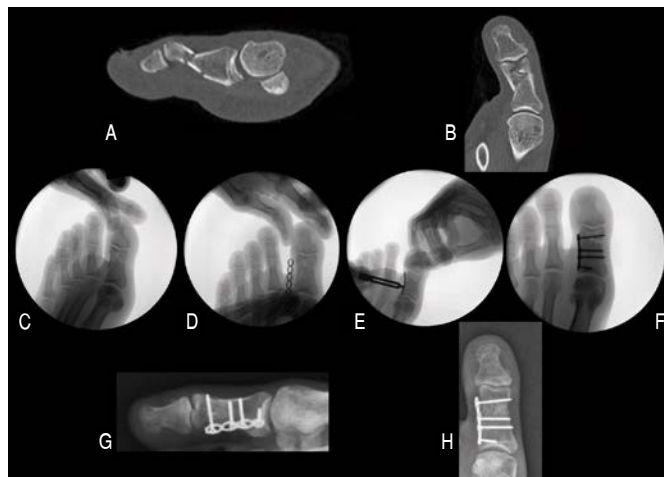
A and B: preoperative CT sagittal and axial view; C: intra-operative hallux distraction; D, E and F: plate cutting in an appropriate length, molding and bending to contour it to the bone; G and H: postoperative oblique and anteroposterior conventional radiographic images of hallux proximal phalanx fracture.
